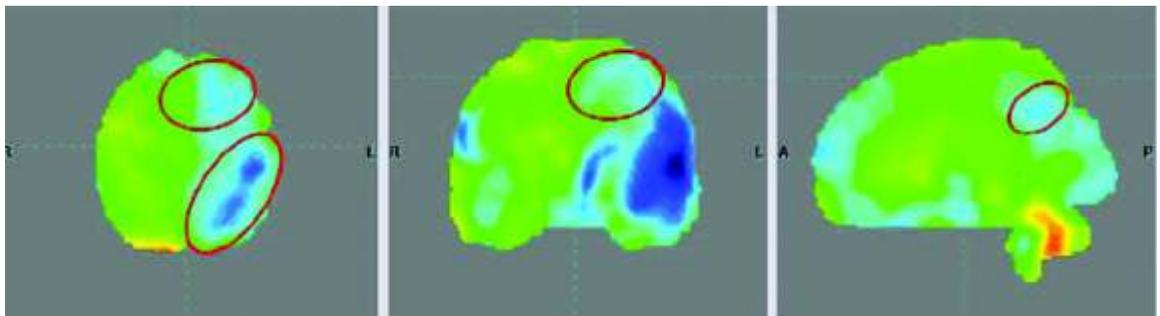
PET-CT scan before Autologous BMMNCs transplantation suggestive of reduced metabolism in the regions of left frontal lobe, occipital lobe and basal ganglia
